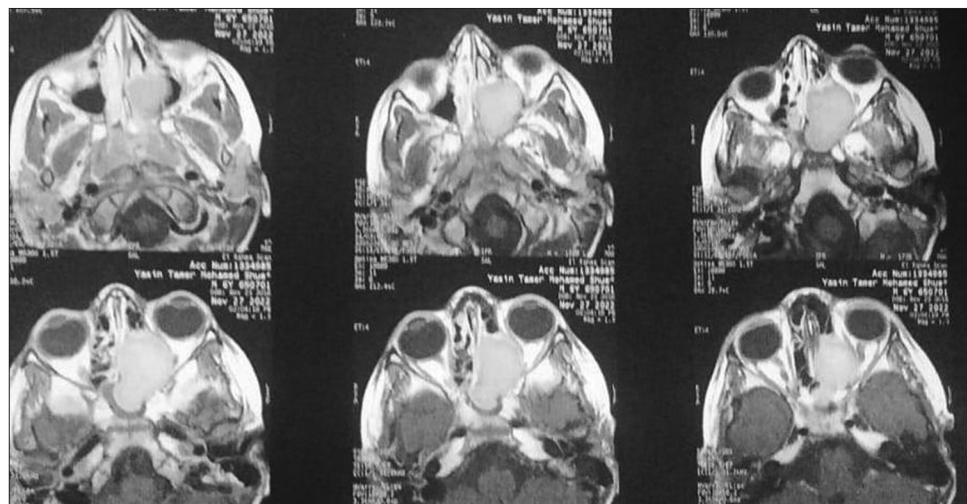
Magnetic resonance imaging-T1-weighted image of paranasal sinuses and the brain (axial cuts) showing a well-defined hyperintense lesion filling the left ethmoid, sphenoid sinuses, and the left nasal cavity.
